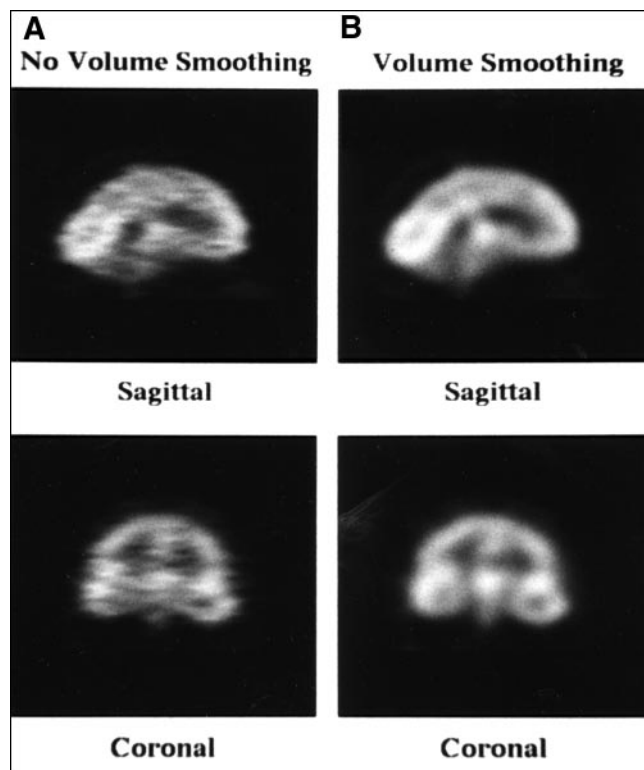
(A) Central sagittal and coronal slices without volume smoothing and (B) with volume smoothing, for a 128×128 ^{99m}Tc -HMPAO brain SPECT study. A 0.3 Nyquist, 10th order Butterworth transverse reconstruction filter was applied to the transverse slices in A, and a 0.375 Nyquist, 10th order Butterworth volume smoothing filter was applied in B, such that the transverse slices had equivalent smoothness. Note the streaking between rows of pixels in A due to no filtering between transverse slices.
